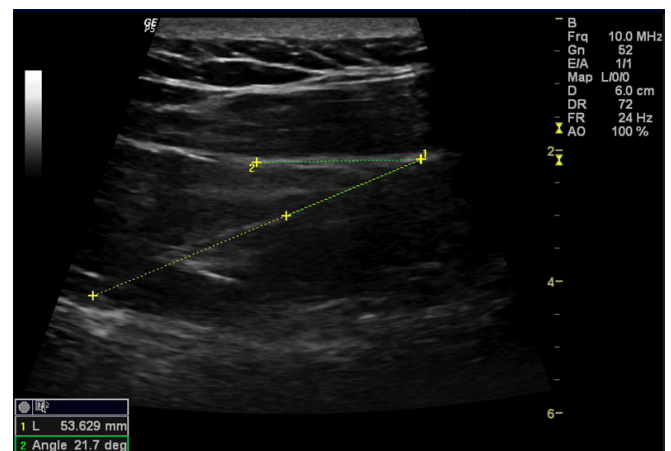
Ultrasonographic imaging of supraspinatus muscle demonstrating the measurement of the pennate angle and fascicle length.
